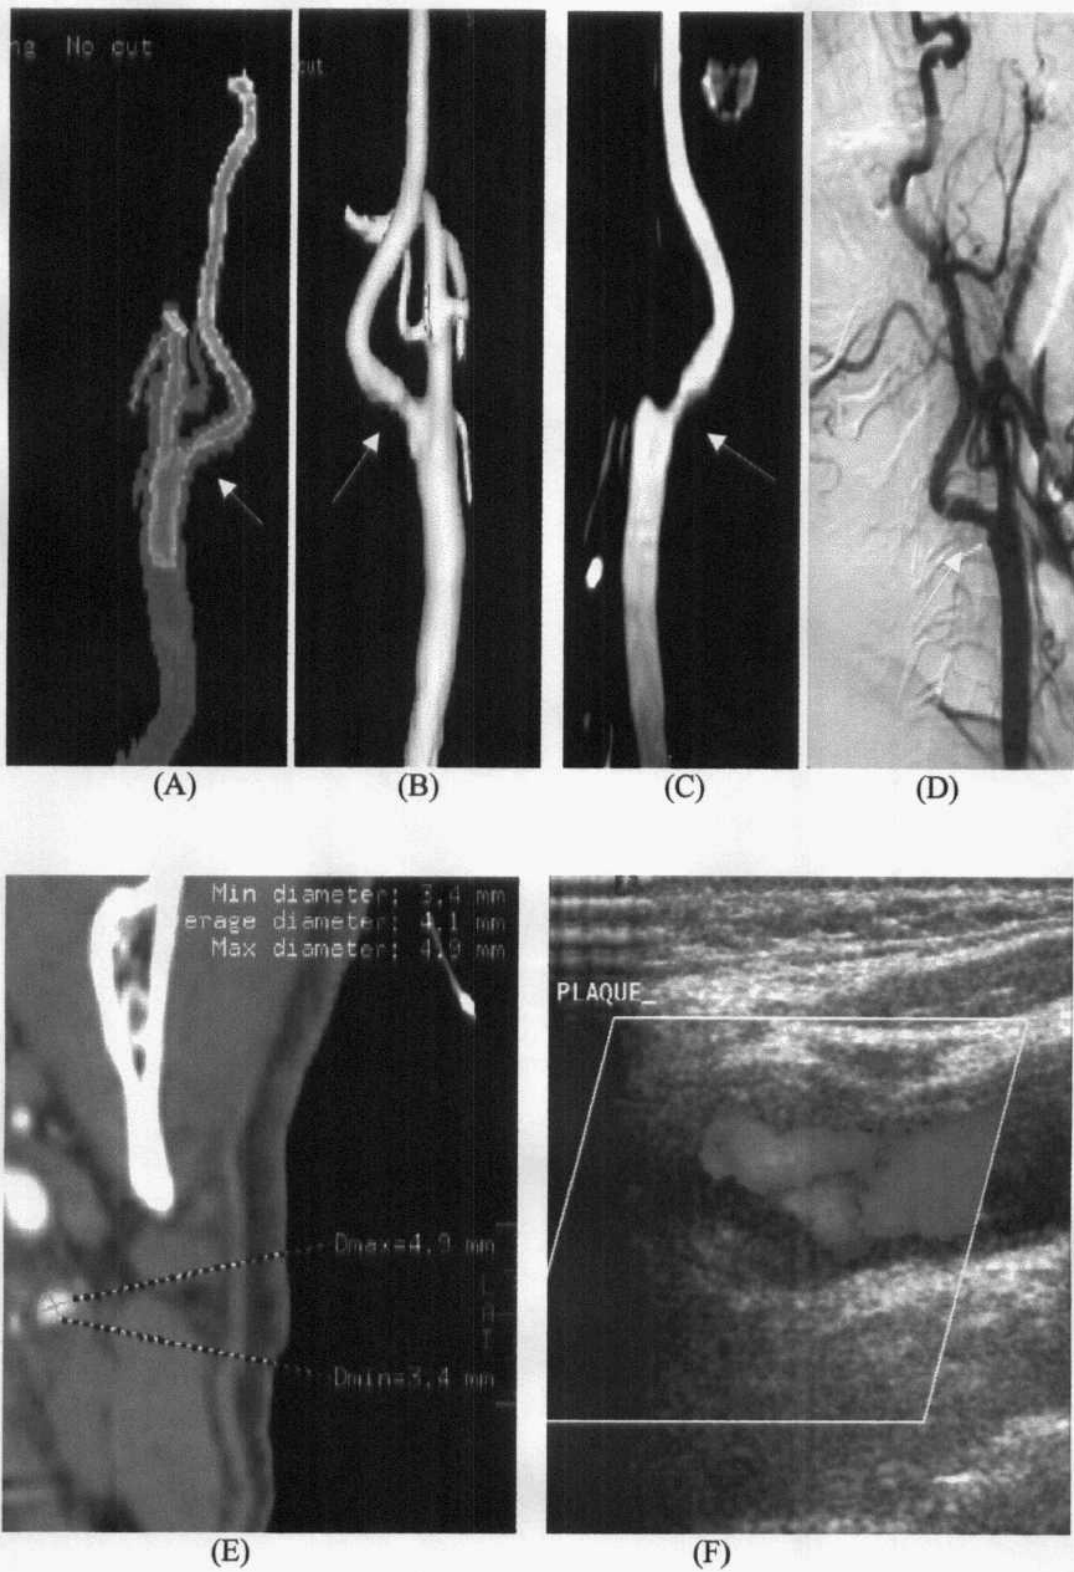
Left ICA stenosis by volume render technique (A), shaded surface display (B), Curved planar reformat (C) Digital subtraction angiography (D), axial CT reformat (E) and color flow Doppler (F).
